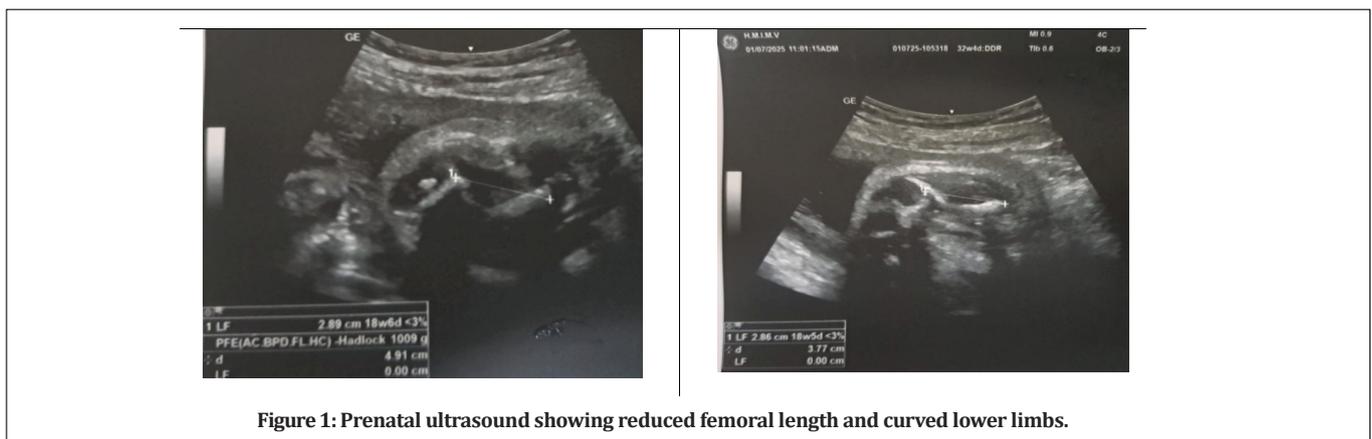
Prenatal ultrasound showing reduced femoral length and curved lower limbs.
